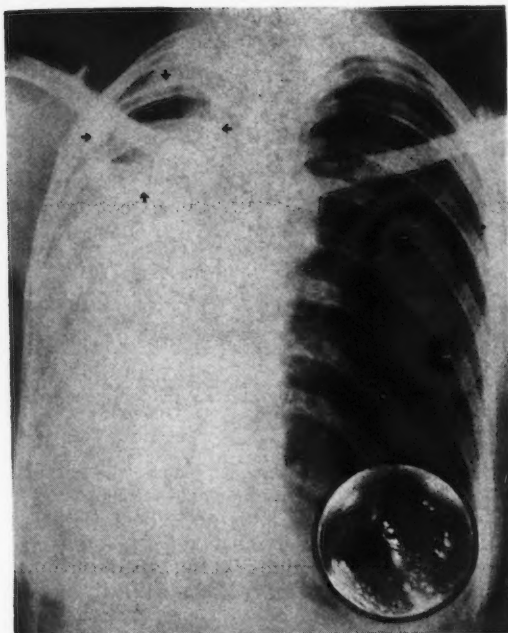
Progressive atelectasis of the right lung with tennis-ball cavity. Insert shows original extent of acute hyperplastic mucosal tuberculosis, limited to the stem bronchus. The tracheal mucosa was later involved. Roentgen therapy resulting in severe lower tracheal and bronchial stenosis. Death. Such a lesion now would be treated with electrocautery when first seen.
